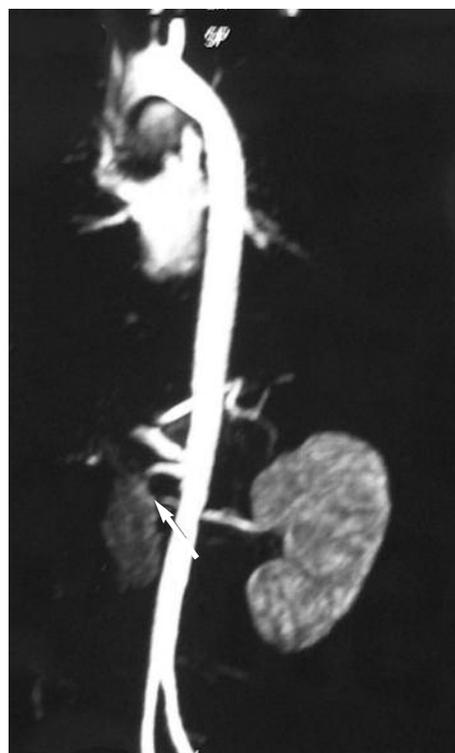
MRI angiography of the renal artery; stenosis in right renal artery (arrow) and shrunken right kidney.
